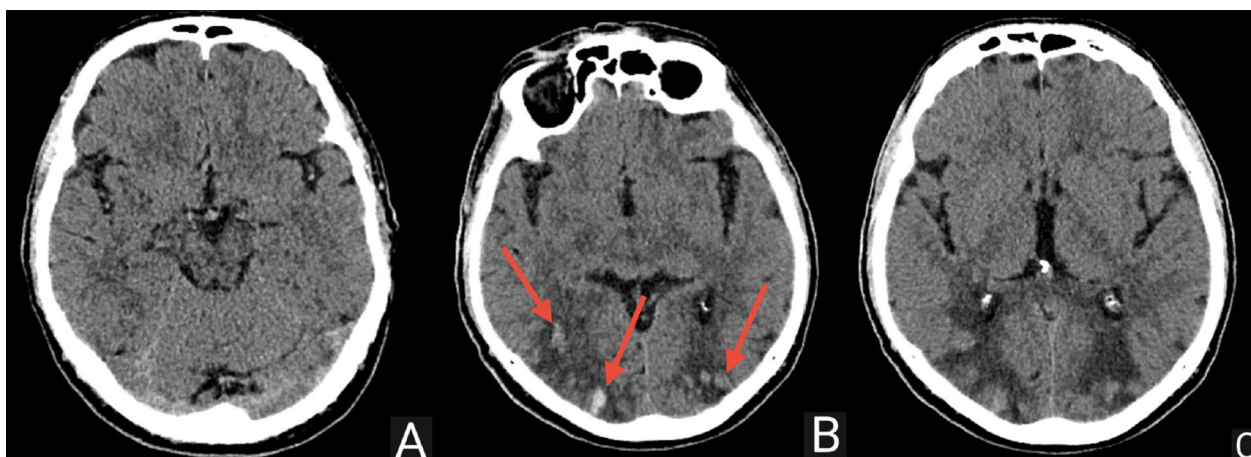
Head computed tomography scans of patient 2 on admission—large bilateral hypodense areas in the occipital and parietal lobes (A). Third day of hospitalization; hemorrhagic foci marked with arrows (B). Tenth day after admission; partial resorption of hemorrhagic changes (C)
